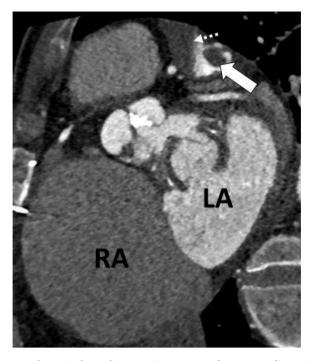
A rheumatic heart disease patient was sent for CCTA to diagnosis of anomalous coronary artery. Left atrial appendage thrombus was incidentally detected (arrow) and slow flow artifact within left atrial appendage also demonstrated (dashed arrow). (CCTA : Cardiac computed tomography angiography, RA : Right atrium, LA : Left atrium).
